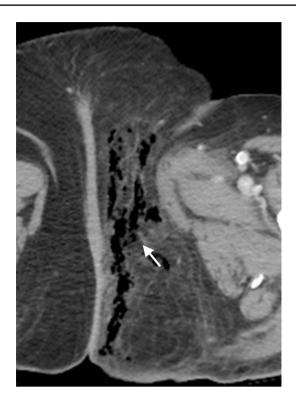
Fournier gangrene in a female. Axial enhanced CT image shows fat stranding and soft tissue gas in the left perineum (arrow)
